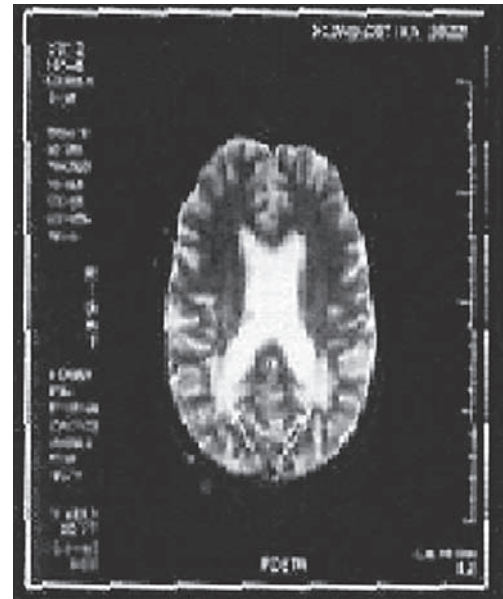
(SE TR 2500, TE 25/110, TR 500, TE20) Cerebral MRI: cerebral atrophy, multiple hyperintensive lesions in the white matter, especially periventricularly, typical of MS lesions.
